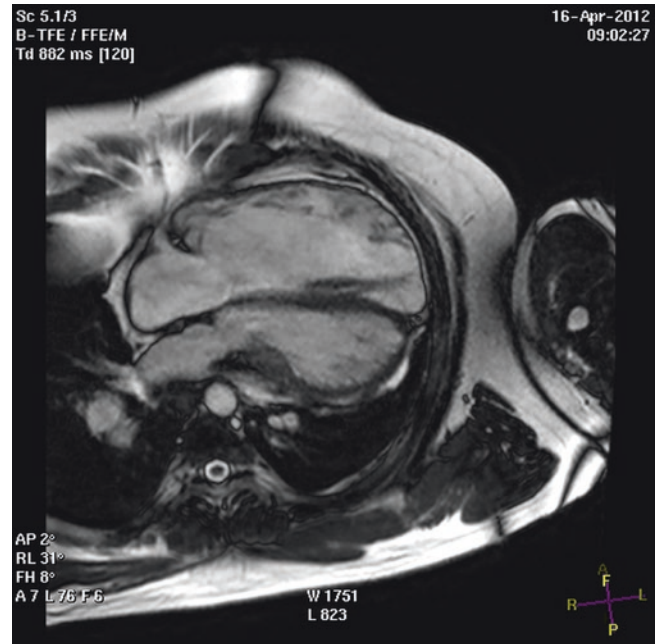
Four chamber end diastolic MR image of a patient with repaired tetralogy of Fallot. The right ventricle is severely dilated, measuring 236 mL/m². (Image courtesy of Dr. Jimmy Lu)
